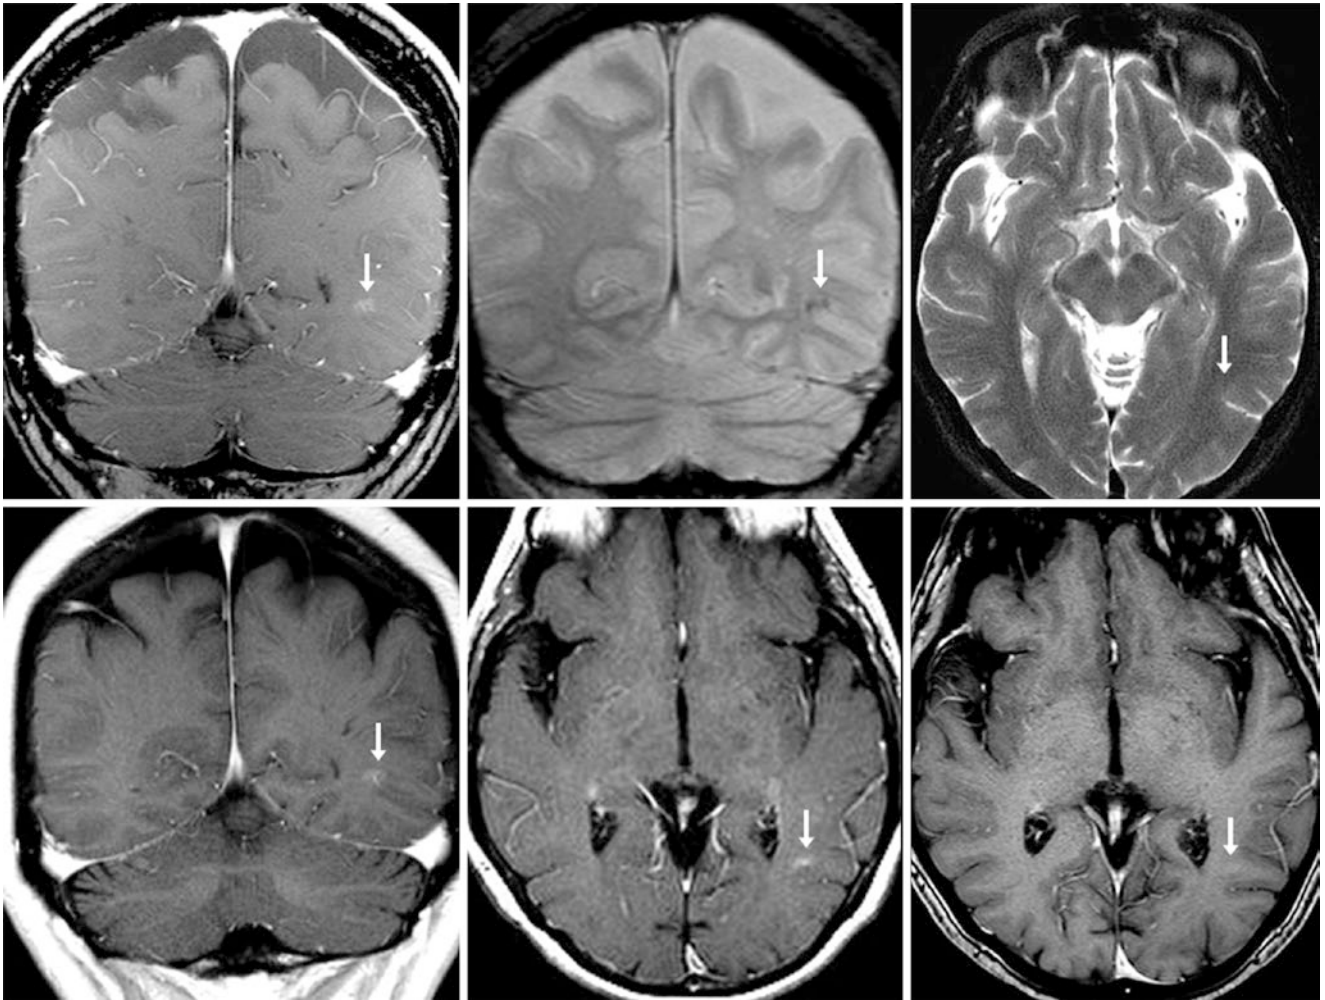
A 64 year old with renal cancer whose 1.5T MRI, post-contrast axial GE T1WI (*top left*) showed a faint parietal focus of enhancement with faint dark signal on coronal T2*WI (*top middle*), and lacking edema on T2WI (*top right*). This was called a BCT; no metastases were noted. Two years later, coronal postcontrast GE (*bottom left*) and axial
